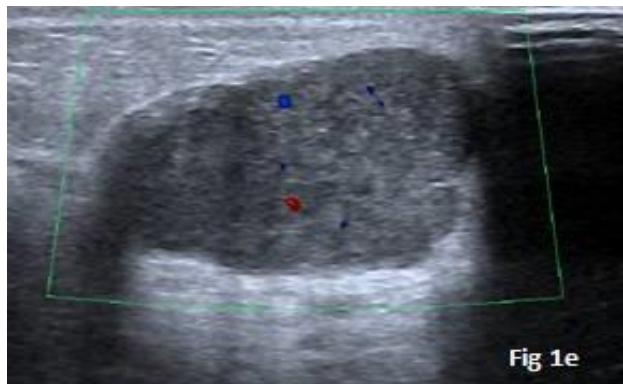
Ultrasound showing intrinsic vascularity.
